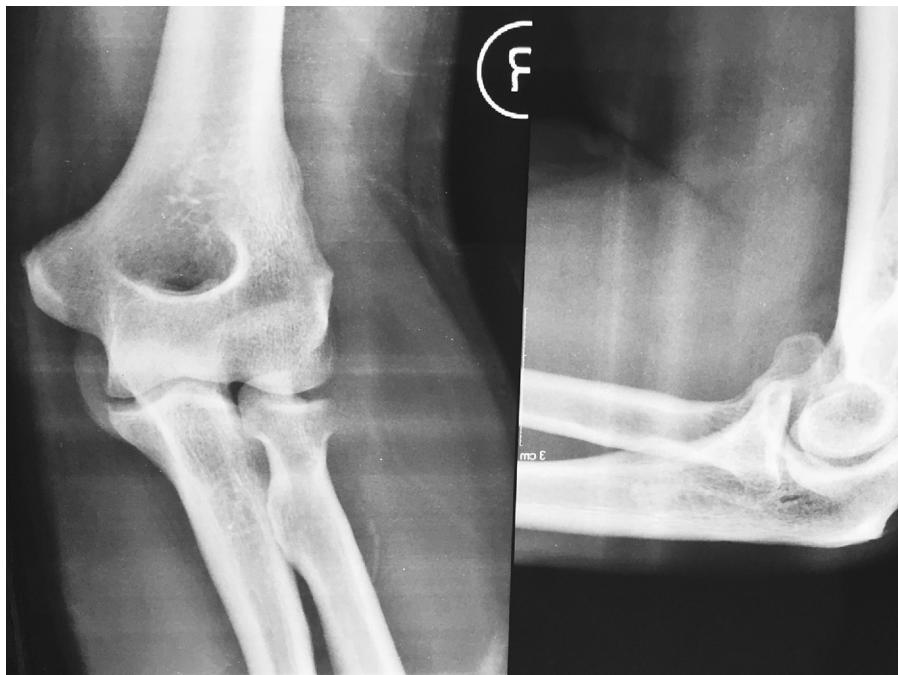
Radiograph in AP and lateral views showing the radial head fracture and anterior displacement of the fragment.
